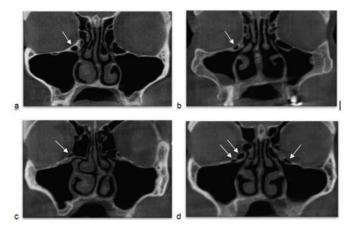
Coronal cone beam CT shows different shapes of Haller cells, a. round, b. oval, c. triangular, d. multiple and bilateral Haller cells
